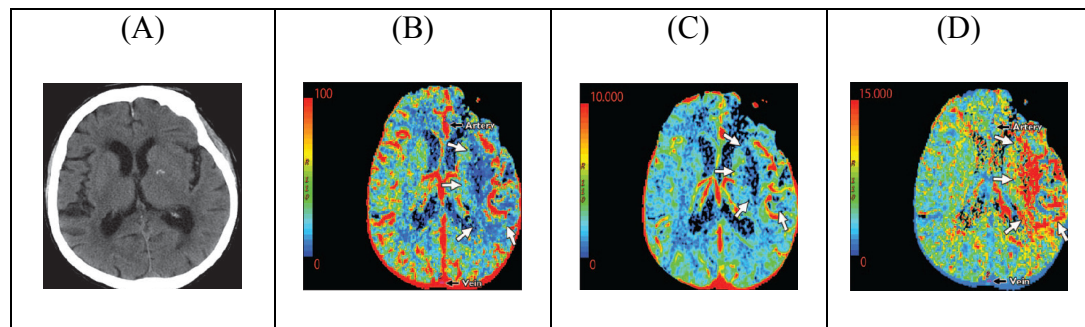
State-of-the-art Multimodal CT Images of an Acute Stroke Patient.
